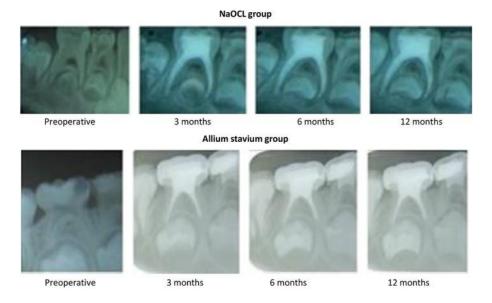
Comparison of periapical radiographs of successful pulpectomy with garlic extract and sodium hypochlorite (NaOCl) on the lower right first molar tooth<sup>15</sup>.
